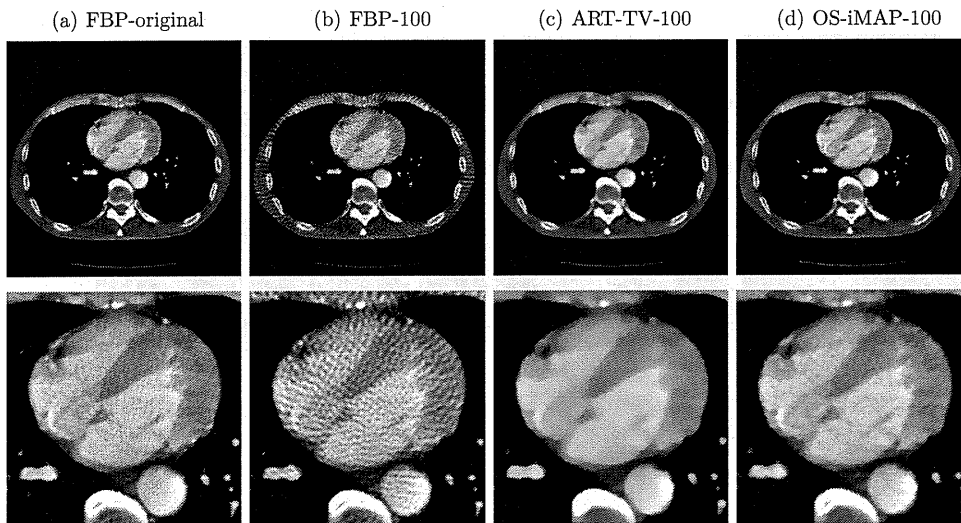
Image reconstruction of the chest CT data. (a) Original slice image and reconstructions from 100 projections using (b) FBP, (c) ART-TV and (d) OS-iMAP methods. A magnification of the cardiac region is shown in the bottom row. Display gray scale is $(0.85, 1.3) \text{ cm}^{-1}$.
